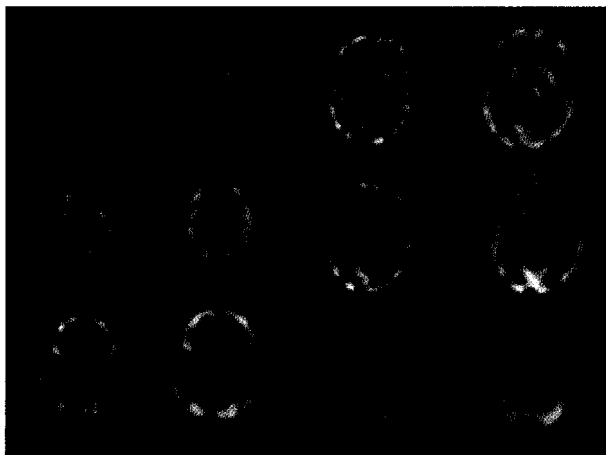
Reconstruction of a SPECT HM-PAO brain perfusion study. Six axial slices are shown. First and third column from the left: conjugate gradient iterative technique with 3D model of the geometrical system response. Second and fourth column from left: backprojection of Wiener filtered projections.
